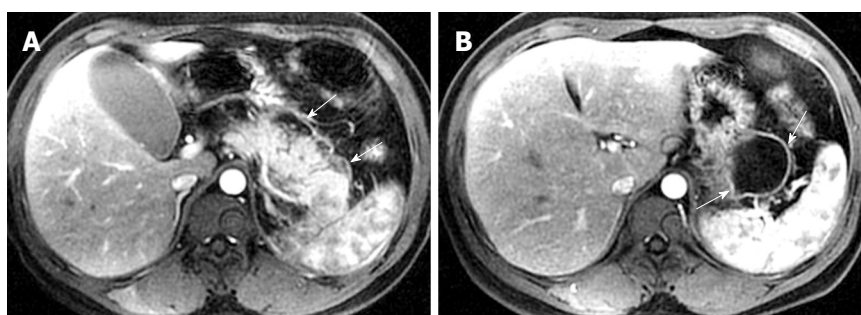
33-year-old man with acute necrotizing pancreatitis and peripancreatic abscess. Contrast-enhanced axial T1-weighted images reveal abnormal peripancreatic enhancement (arrows, A) and a liquid-like mass with a well-defined, thickened, and enhancing wall (arrows, B).
